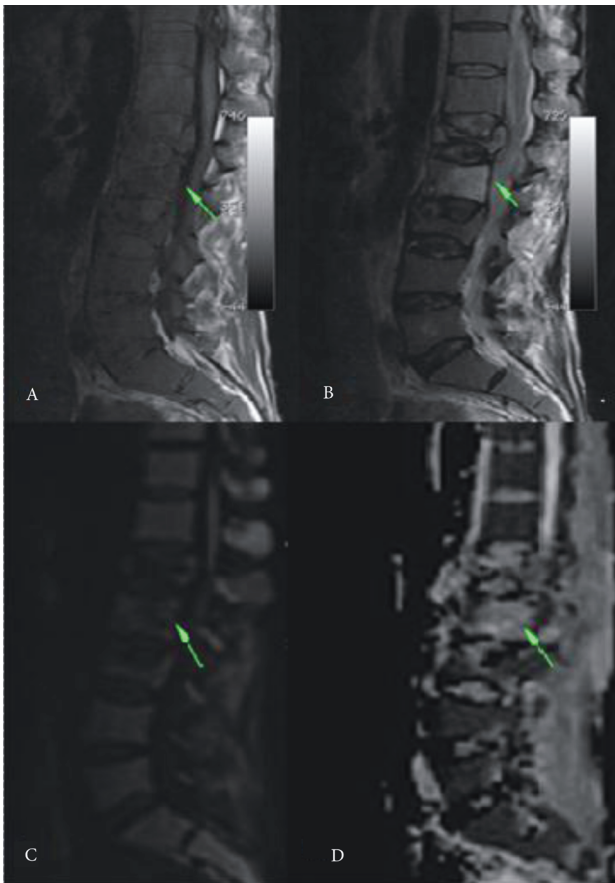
A–D. Atypical hemangioma of the spine (L2) in a male patient followed up for chronic lymphoid leukemia. The T1-weighted axial MR image (A) shows hypointensity in the round lesion with smooth contours (arrow). The T2-weighted axial MR image (B) shows hyperintensity in the lesion (arrow). DWI (C) shows hypointensities in these lesions due to increased diffusion (arrow). The ADC map (D) shows hyperintensity in the lesion (arrow). The mean ADC value is $2.82 \times 10^{-3} \text{ mm}^2/\text{s}$ at the ADC measurements of the lesion and supports a benign lesion. There are also benign compression fractures that do not show diffusion limitation at the L1 and L3 vertebrae.
